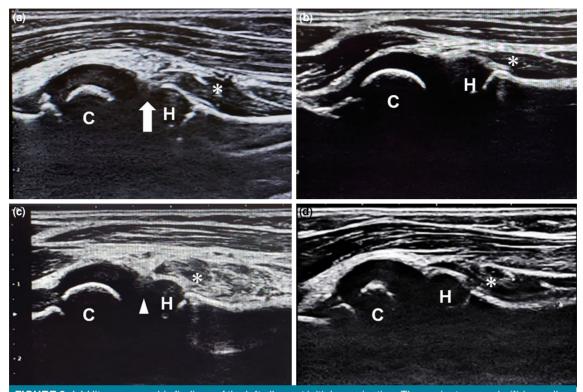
(a) Ultrasonographic findings of the left elbow at initial examination. The supinator muscle (\*) is swollen and entrapped in the radiohumeral joint, and the joint space is enlarged (white arrow). (b) Ultrasonographic findings of the right elbow. No inclusions in the radiohumeral joint and no swelling of the supinator muscles are noted. (c) Ultrasonographic findings of the left elbow 4 days after initial examination. The joint space enlargement has resolved (white arrow head), but the supinator muscle is still swollen. (d) Ultrasonographic findings of the left elbow 11 days after initial examination. The swelling has significantly improved.
